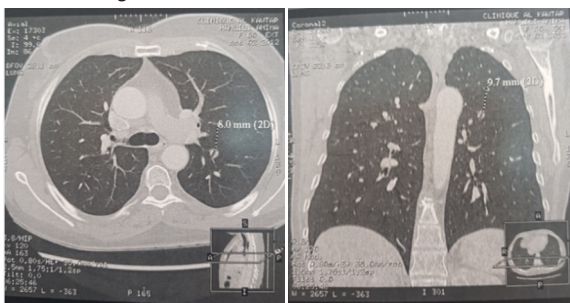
CT of the thorax: Pre-treatment scan shows a diffuse pulmonary metastases
